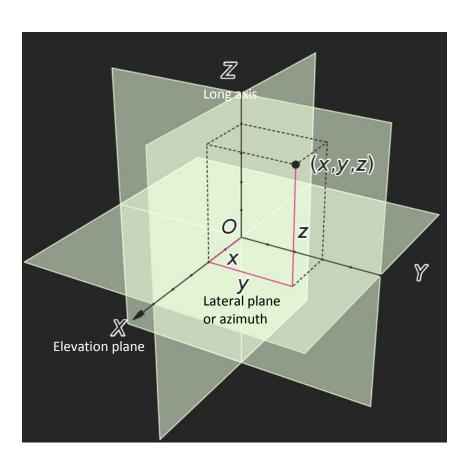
Planes and directions of movement of the three-dimensional coordinate system of the ultrasound transducer (represented by the cube).²
